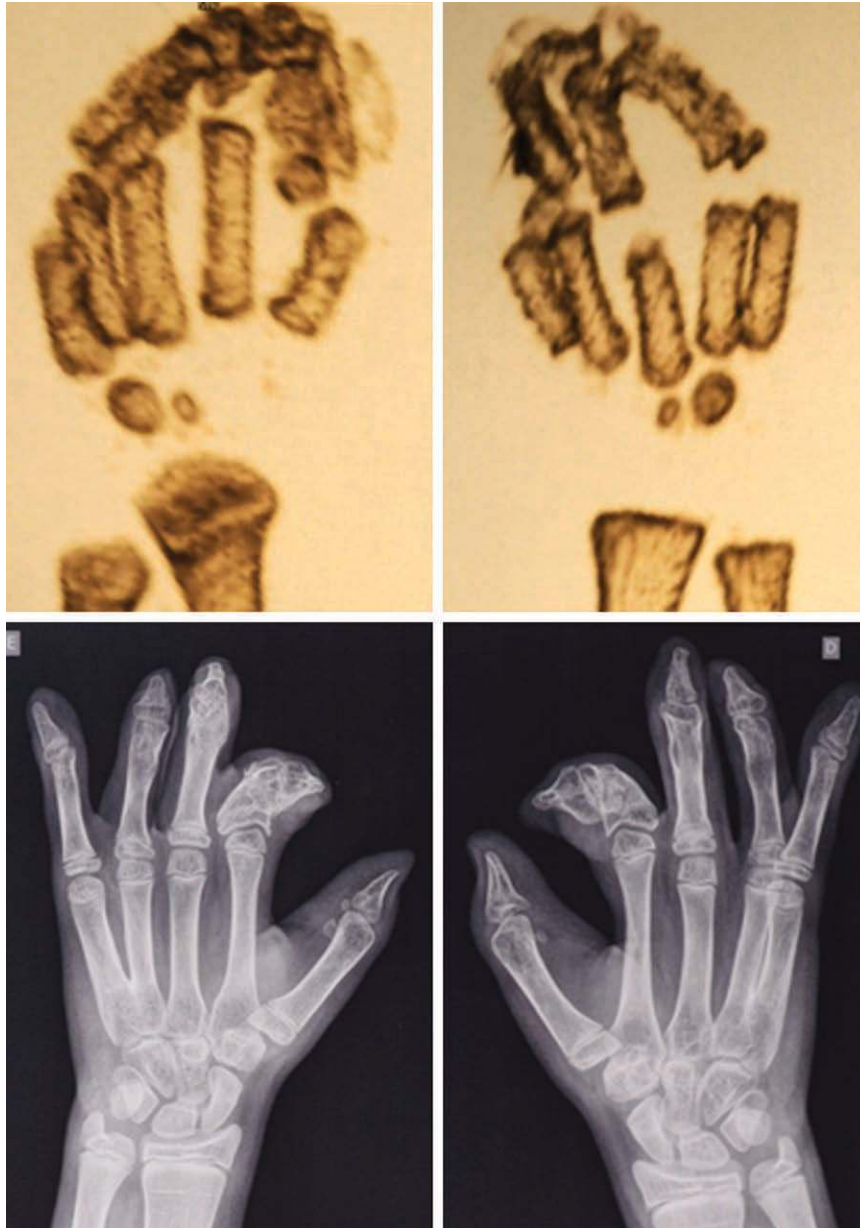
(Above) Preoperative reformatted computed tomographic scan of the same patient as shown in Figure 6. Computed tomographic scans in Upton type III hands facilitate a more accurate visualization of the deformity. (Below) Postoperative radiographs of a five-digit hand after three operations.
